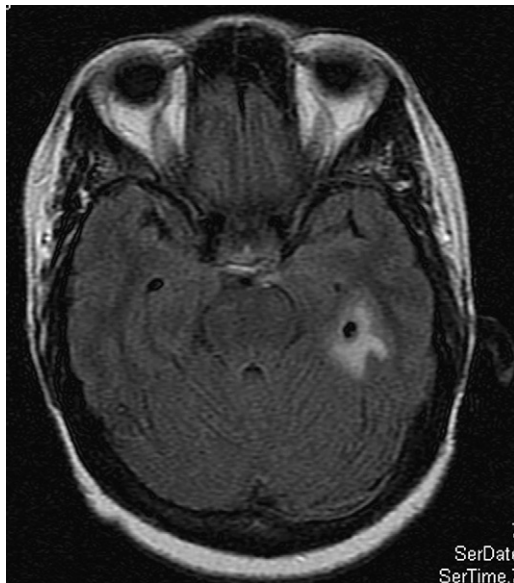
A 46-year-old patient with new-onset seizure. A Haitian native, the patient was last there more than a decade earlier. Isolated cysticercus scolex seen with small amount of surrounding vasogenic edema on FLAIR MRI image.
